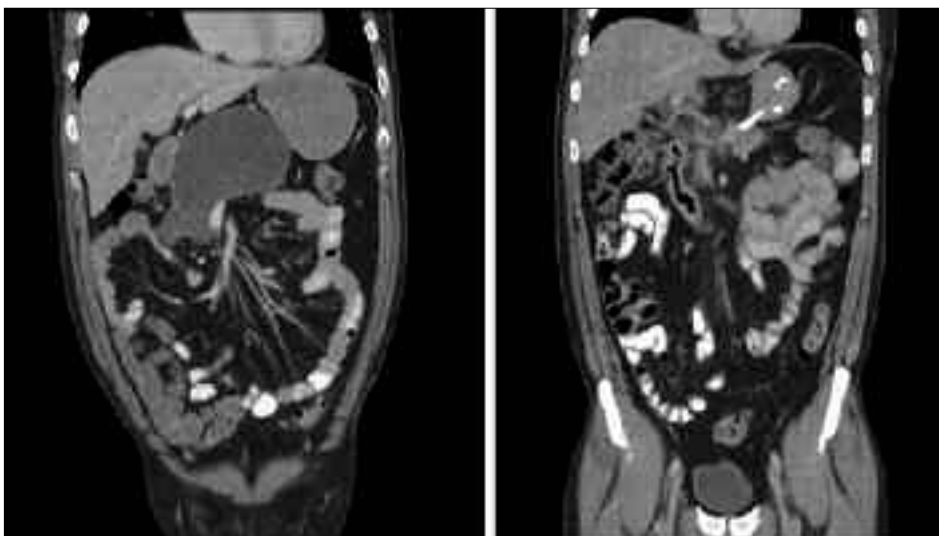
Computed tomography showing a pseudocyst (left) and endoscopically placed pseudocyst-gastrostomy stent with almost complete resolution (right)
